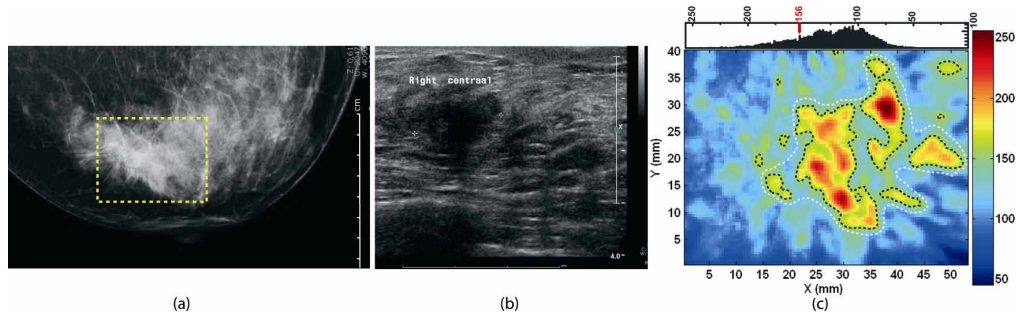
Case 1 of 50 year old woman with invasive ductal carcinoma in right breast. (a) Craniocaudal x-ray mammogram reveals architectural distortion with spiculations. Window shows expected location of the ROI for the photoacoustic scan. (b) Transverse sonographic scan image shows 17 mm irregular hypoechoic solid mass. (c) Craniocaudal photoacoustic MIP image in top-view reveals higher intensity regions attributed to tumor vascularization. Contour lines (black dotted) are drawn using the level indicated in the image histogram above. The possible extent of the tumor mass (major axis 35 mm) is indicated by the white dotted line encompassing the cluster of vascular regions. The photoacoustic image cannot be compared point by point with the x-ray image in ROI due to differences in compression and in ROI positioning.
